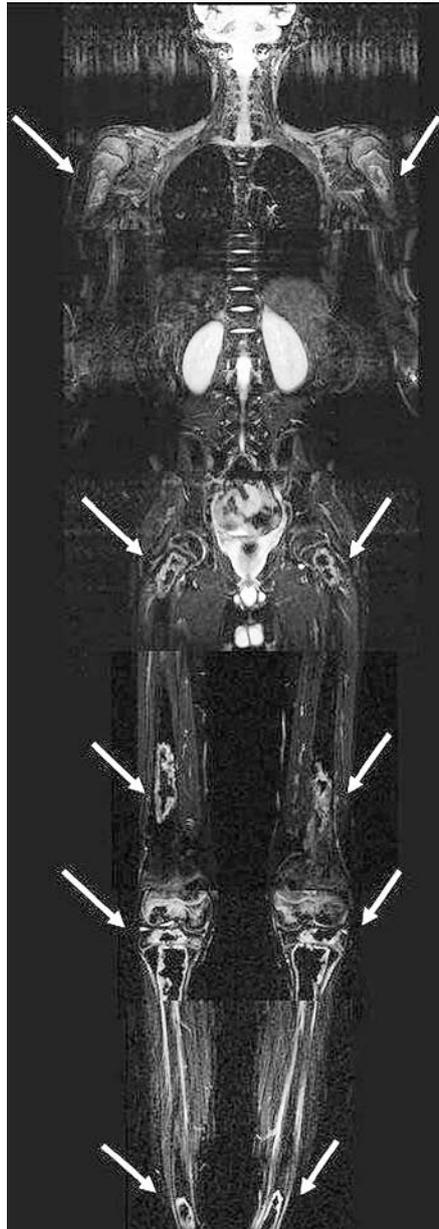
16 year old boy with c-ALL. Whole body MR-imaging with T2-weighted sequences (TIRM) at the onset of clinical symptoms demonstrates typical lesions of multiple osteonecrosis in both humeri, femora and tibiae (white arrows). The conventional X-rays showed no pathologies at the same time.
